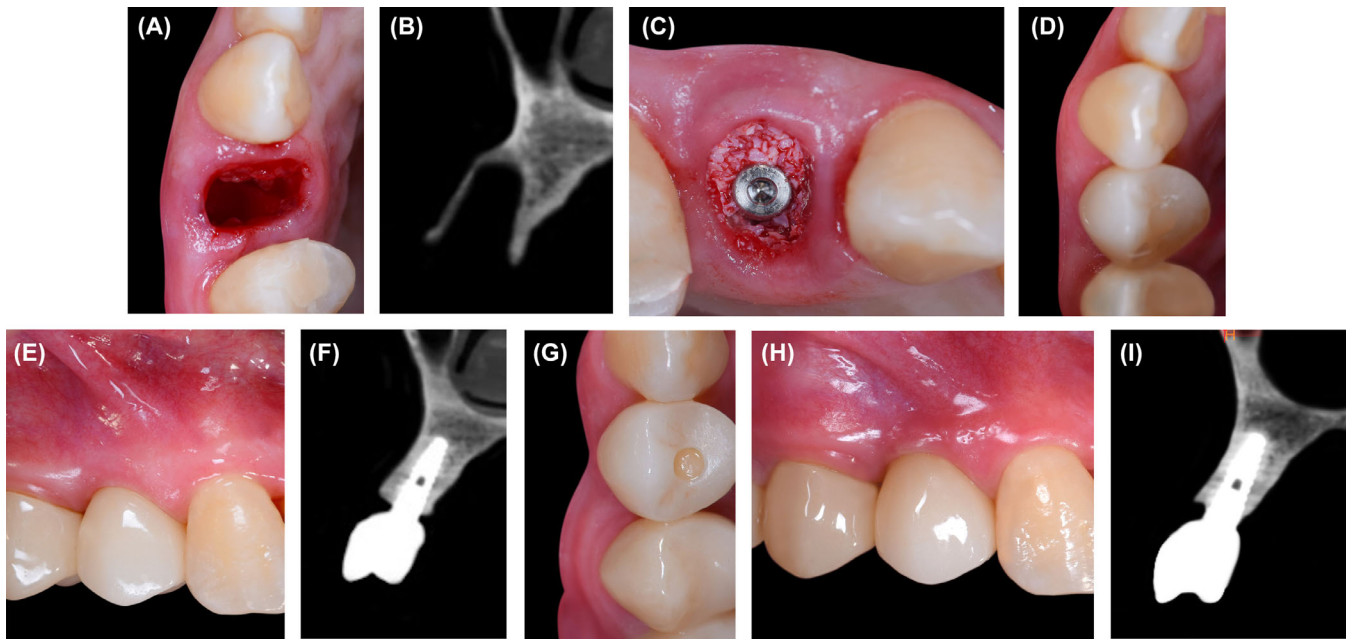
(A) Preoperative view of bicuspid fresh extraction socket. (B) Cone beam computed tomography (CBCT) showing the thin intact walled buccal plate of bone. (C) The implementation of the dual-zone concept. (D) Immediate post restorative clinical photograph incisal view. (E) Immediate post restorative clinical photograph frontal view. (F) Immediate CBCT scan post dual-zone concept. (G) 1 year post restorative clinical photograph showing the drop of the facial contour incisal view. (H) 1 year post restorative clinical photograph showing the drop of the facial contour frontal view. (I) 1 year post restorative CBCT showing reduction in the buccal bone size because of the postextraction bone remodeling.
